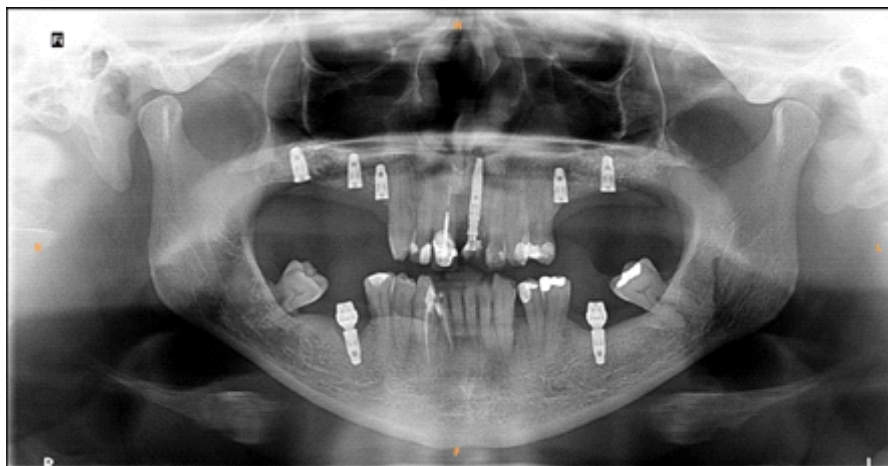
Final panoramic radiograph taken 8 months after the maxillary implants insertion.
